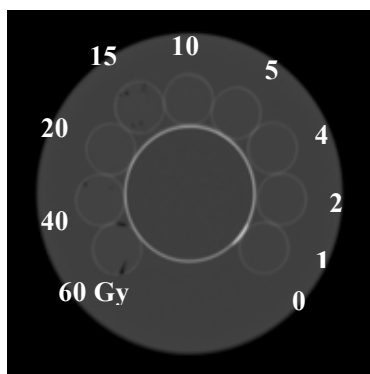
Computed tomography image of the gel.
